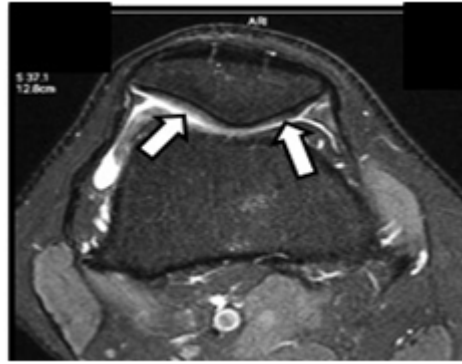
MRI Axial Image shows cross section of patellar cartilage (white arrows)
